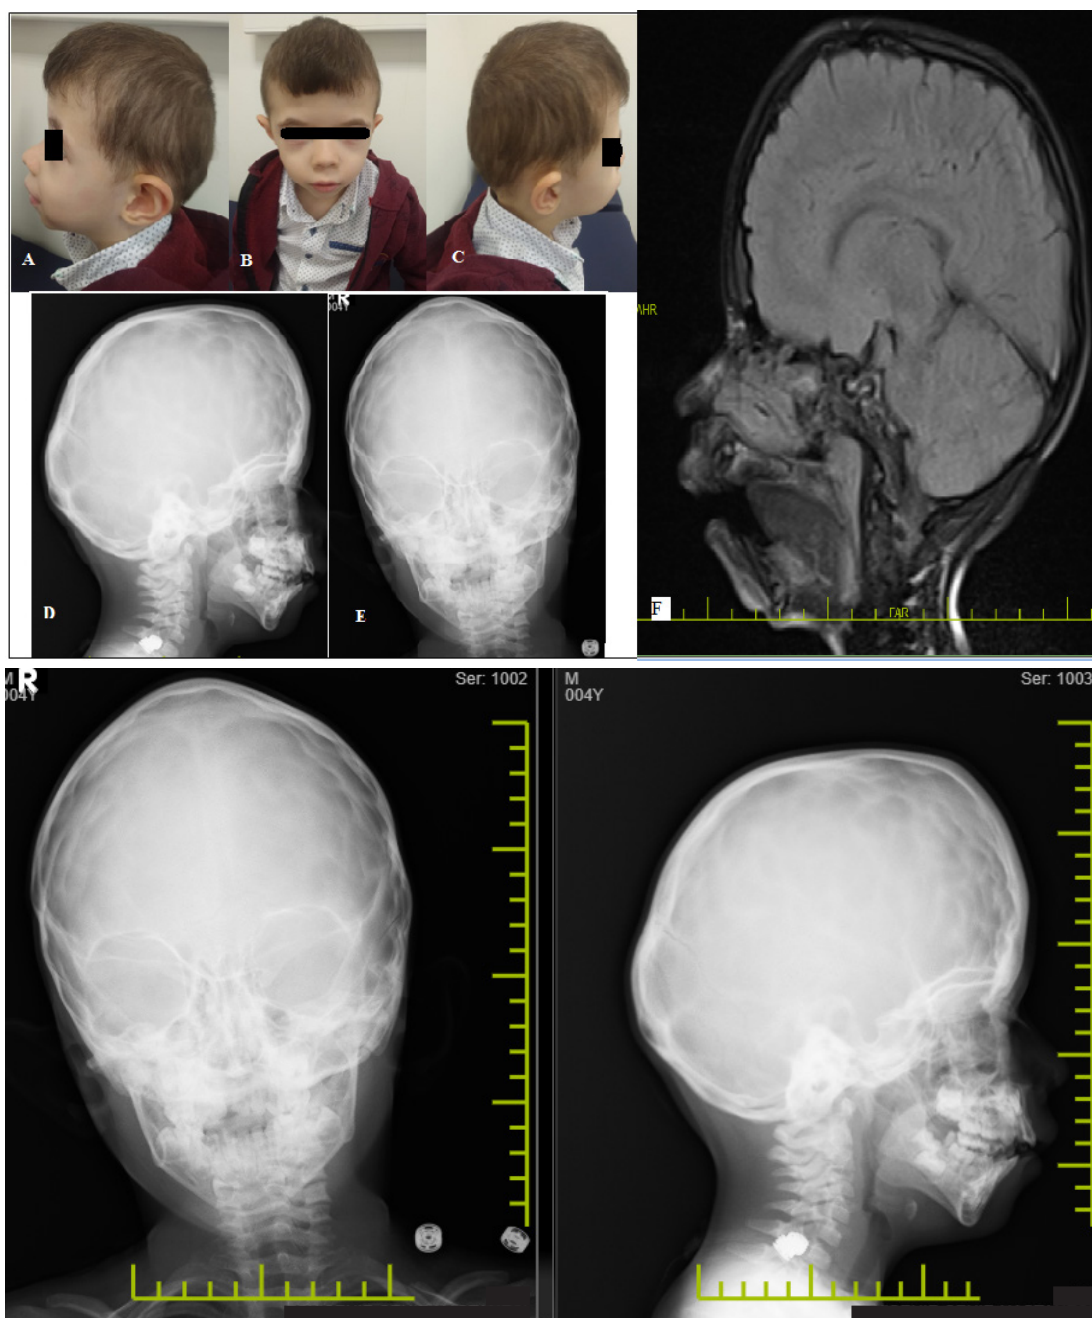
Patient's craniofacial manifestations. A, B and C. The patient has a large forehead, brachycephaly, microcephaly, hypertelorism, telecanthus, a depressed nasal bridge with thick nasal alae and septum, downslanted palpebral fissures, low-set and prominent ears, and retrognathia. The figures are published with the consent of the patient's parents. Skull radiographs, lateral (D) and anterior-posterior (E), views show convoluted markings appearing as a copper beaten skull.
